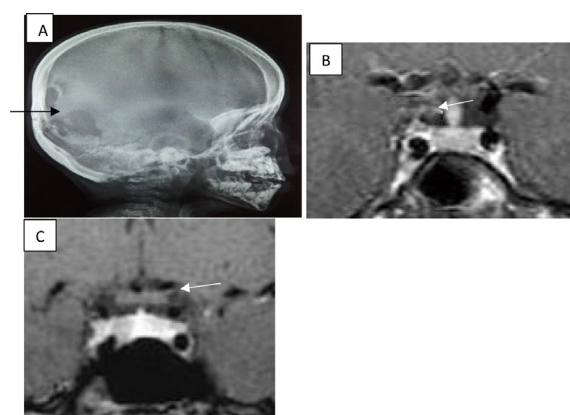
Cranial X ray with MRI images of subject with LCH
